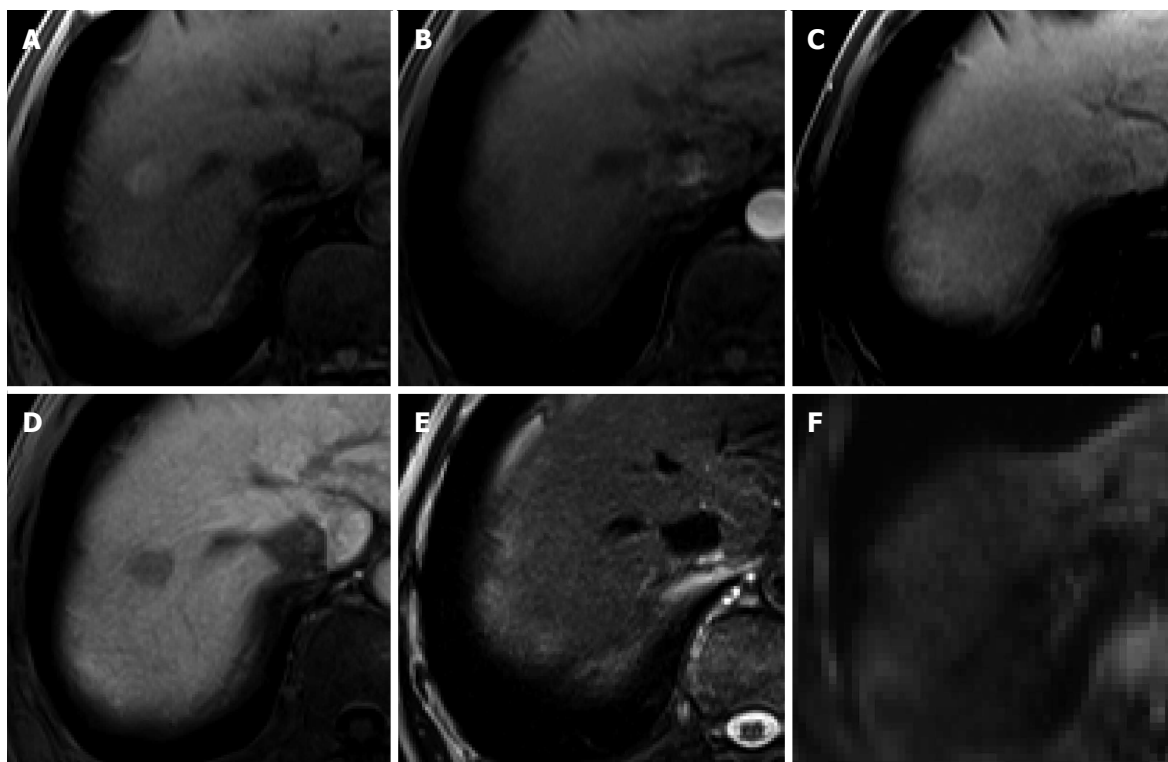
Dysplastic nodule in the same patient as Figure 1. A: precontrast T1-weighted image shows a hyperintense nodule in segment 8, suggesting high contents of iron or copper; B: Hepatic arterial phase of gadoxetic acid-enhanced MRI shows isointensity of the tumor; C, D: transitional and hepatobiliary phases show hypointensity of the tumor relative to the liver parenchyma; E, F: T2-weighted image and diffusion weighted image ($b = 800$) show isointensity of the tumor.
